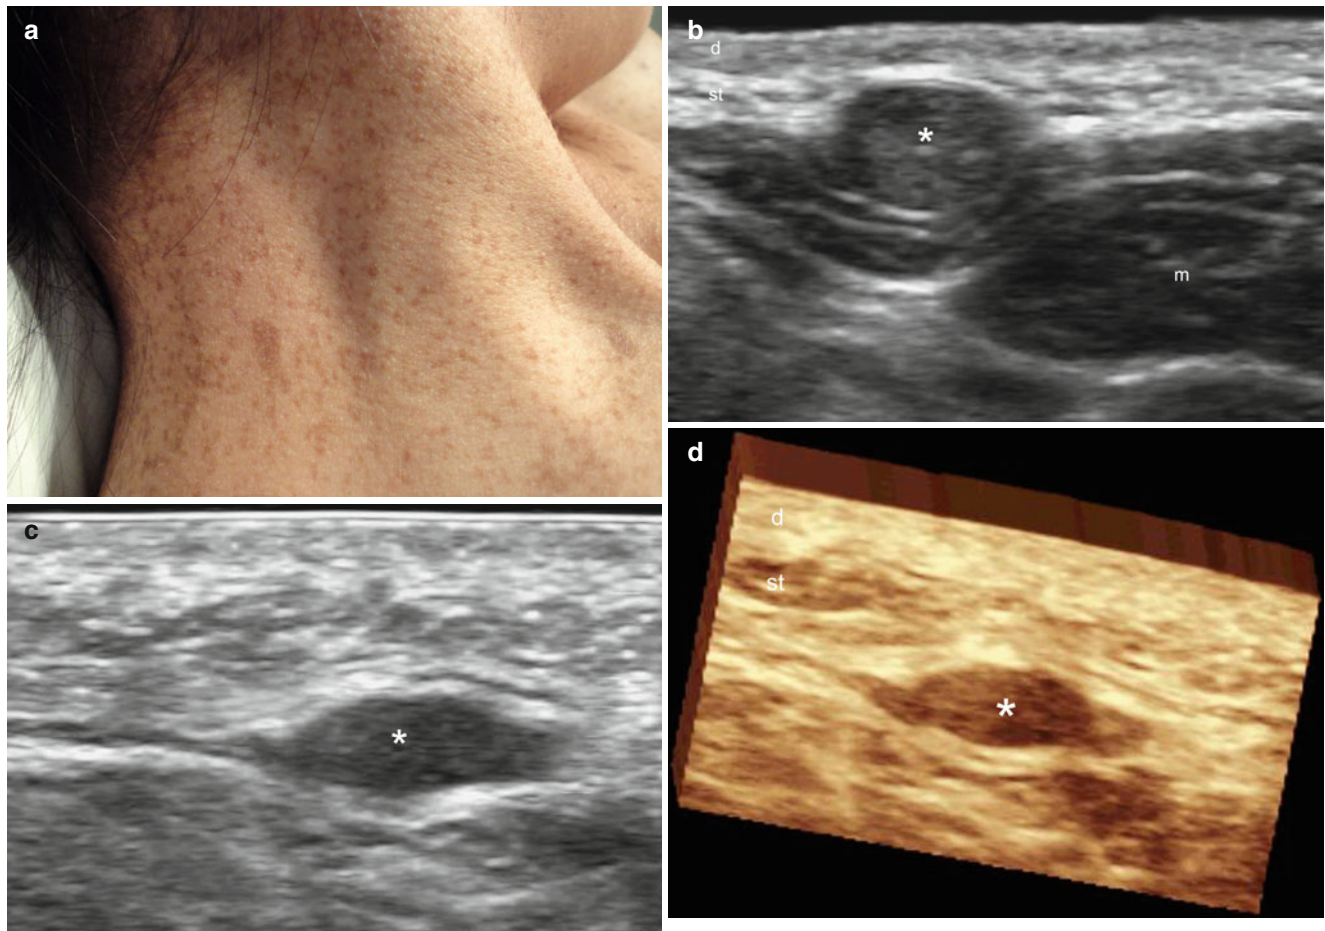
(a–d) Localized neurofibroma. (a) Clinical image shows multiple cafe-au-lait spots in the neck region. (b) Grey scale ultrasound image (transverse view, right aspect of the neck) demonstrates a well-defined, round-shaped nodule (*) in the subcutaneous tissue. (c) Grey scale ultrasound image (longitudinal view, medial aspect of the right
